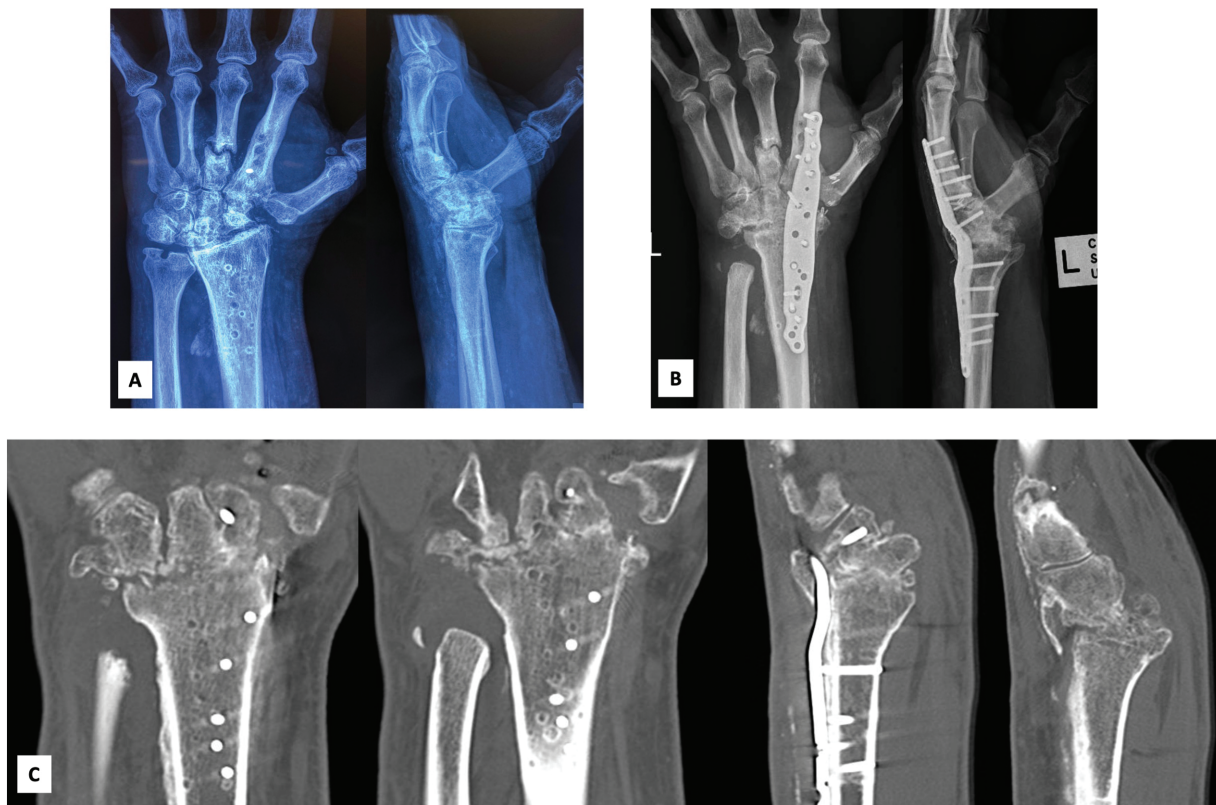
Case 2: a 65-year-old man. (A) Initial presentation to our institution after three failed attempts of total wrist fusion. Note previous fixation to the third and second metacarpals. (B) The patient subsequently underwent revision spanning fixation to the second metacarpal and a free MFC-CP flap. (C) At 4 months, CT scan confirmed bony union across the radiocarpal joint in both the coronal and sagittal planes.
